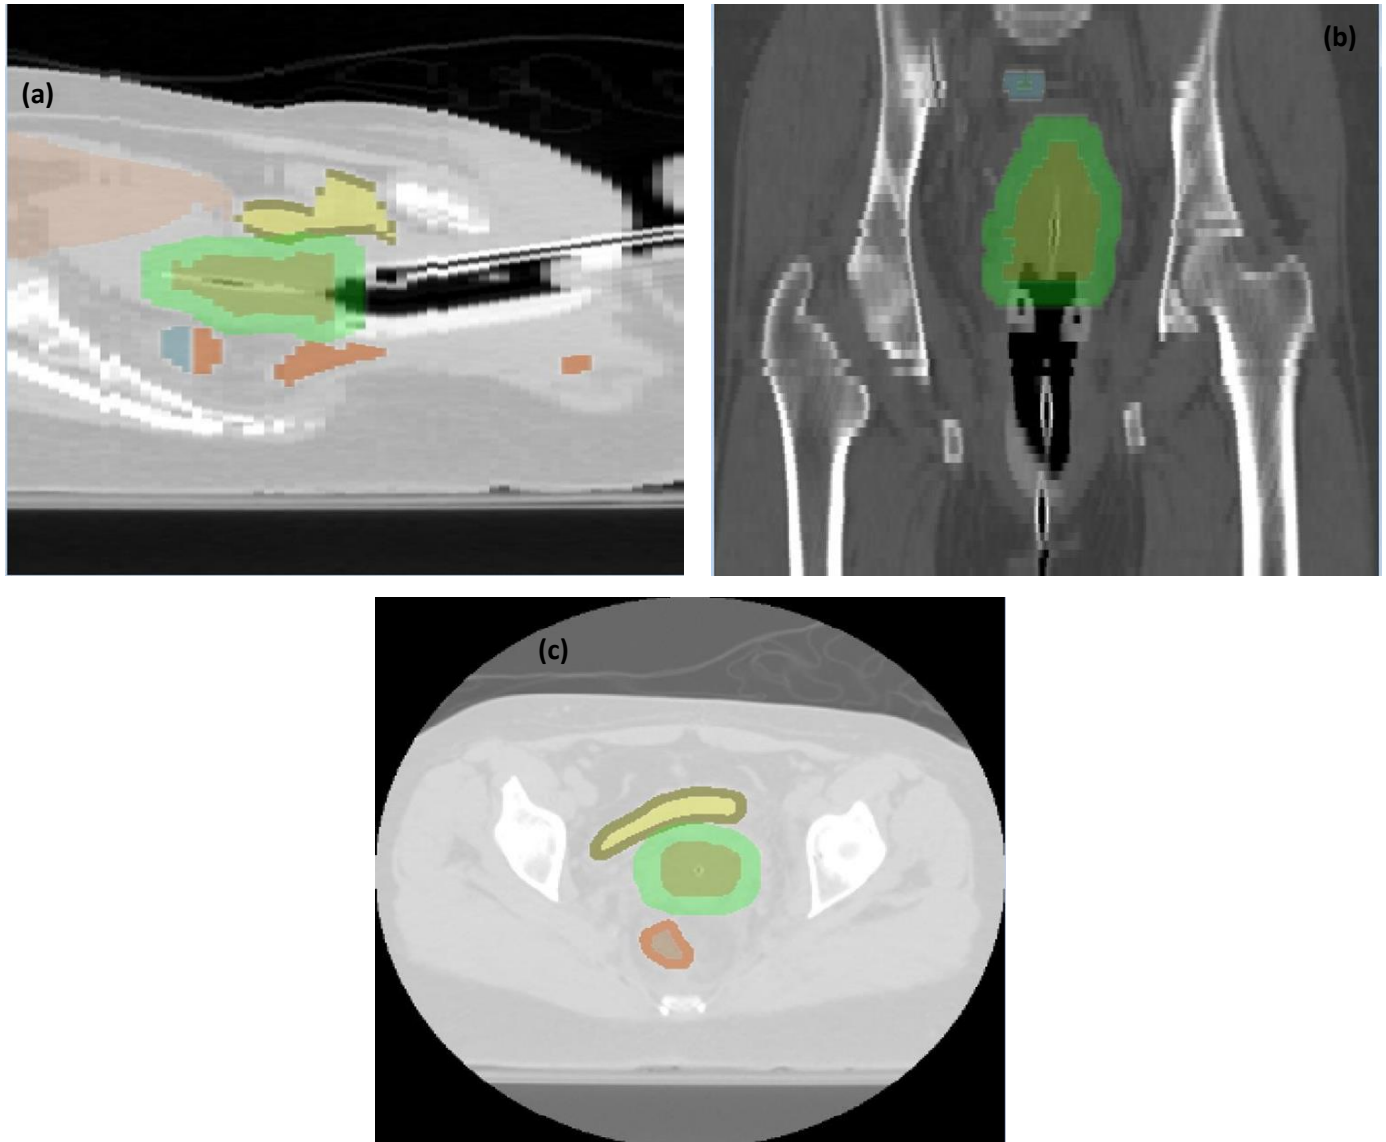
Visualisation of contoured volumes superimposed on CT data in three anatomical planes by the IHDM. (a) Sagittal view, (b) Coronal view and (c) Axial view.
